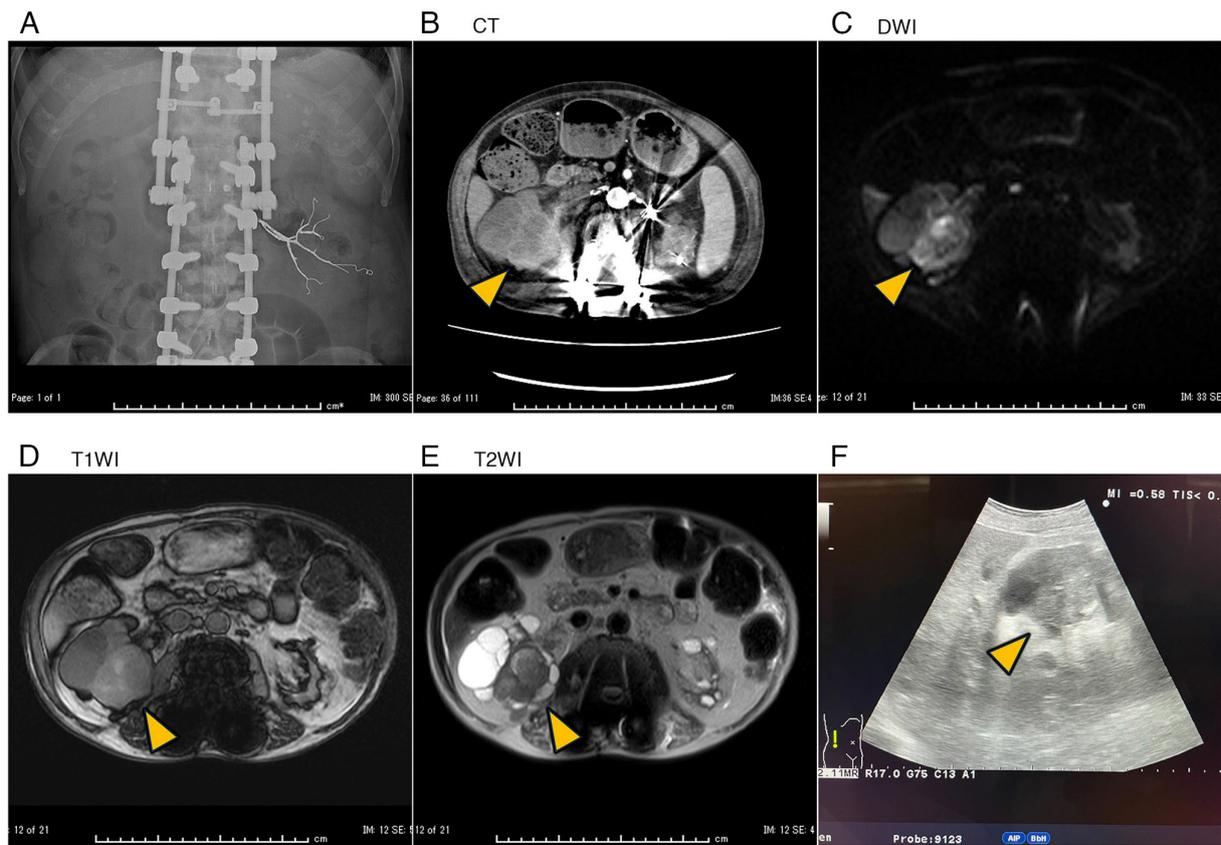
Kidney imaging findings. (A) Abdominal X-ray image after renal transcatheter artery embolization with platinum microcoils. The left kidney only was embolized due to renal artery stenosis in the right kidney. (B) Contrast-enhanced CT image. The cyst wall of the right kidney appears thickened (arrowhead). (C-E) MRI images of the kidney. The cyst was shown with decreased diffusion intensity in (C) DWI, slightly high intensity in (D) T1WI, and low intensity in (E) T2WI (arrowhead). (F) Ultrasound image of the right kidney: A highly echoic mass (~4 cm in diameter) was identified in the cyst (arrowhead). CT, computed tomography; DWI, diffusion-weighted imaging; T1WI, T1-weighted imaging; T2WI, T2-weighted imaging.
